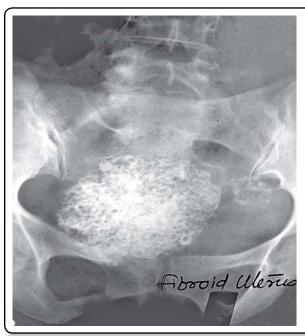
Plain X-ray of the pelvis and lower abdomen showing the calcific degeneration of a fibroid (popcorn appearance).
